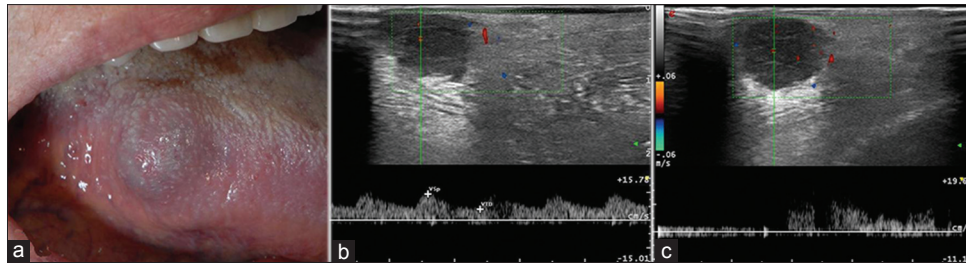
(a) Clinical aspect arteriovenous malformation of the tongue. (b) Color-Doppler US image shows a hypoechoic lesion with lobulated margins with some color-flow signal within it with spectral features compatible with arterial flow. (c) Color-Doppler US with spectral analysis reveals a venous waveform in a different vessel
